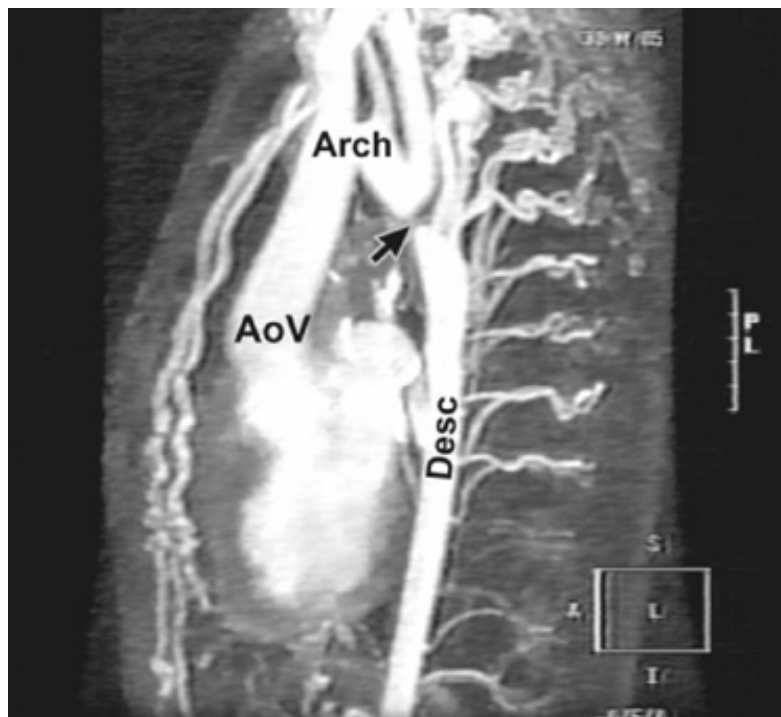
Real-time three-dimensional CT reconstruction of the thoracic aorta in a patient with coarctation (arrow) distal to the left subclavian artery. AoV, aortic valve. Desc, descending thoracic aorta.
